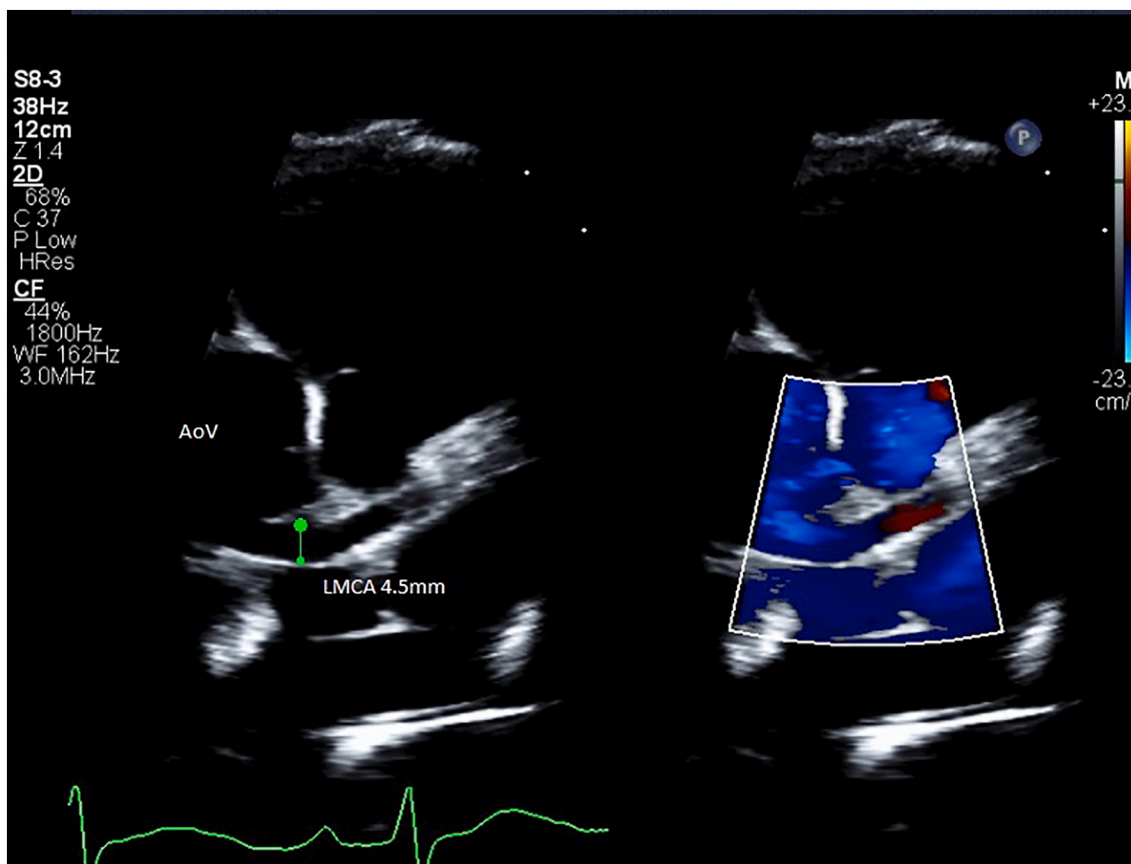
Echocardiogram showing trivial dilation of left coronary artery. AoV: aortic valve; LMCA: left main coronary artery.
